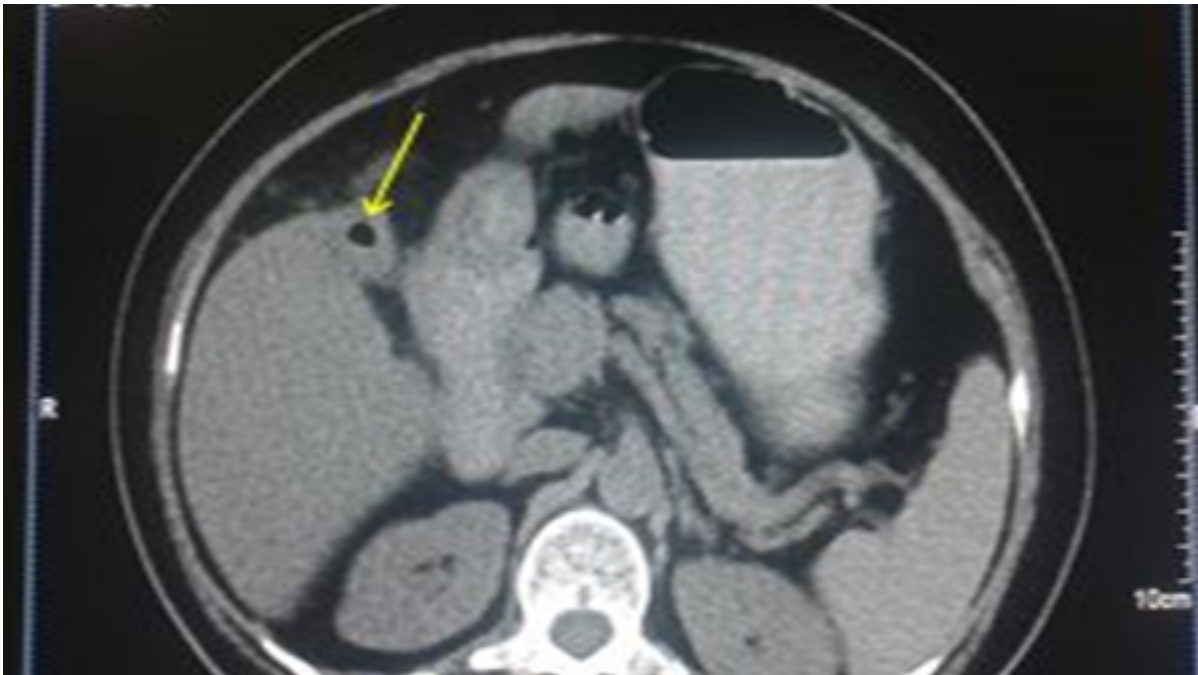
Axial section of abdominal computed tomography shows collapsed Gallbladder with air within.
